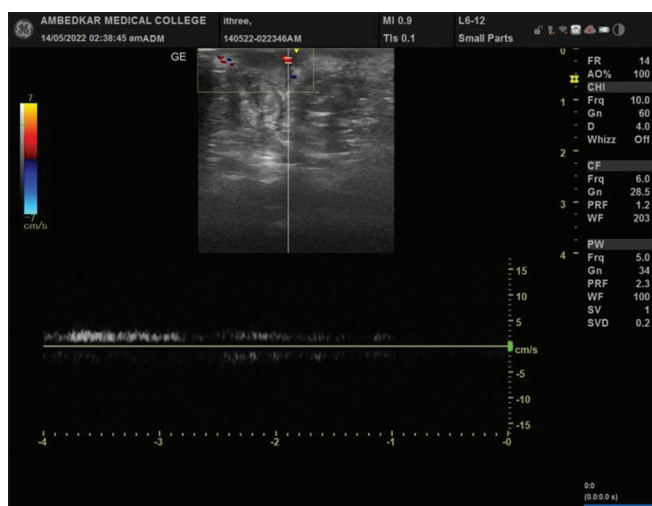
Doppler showing monophasic blood flow
